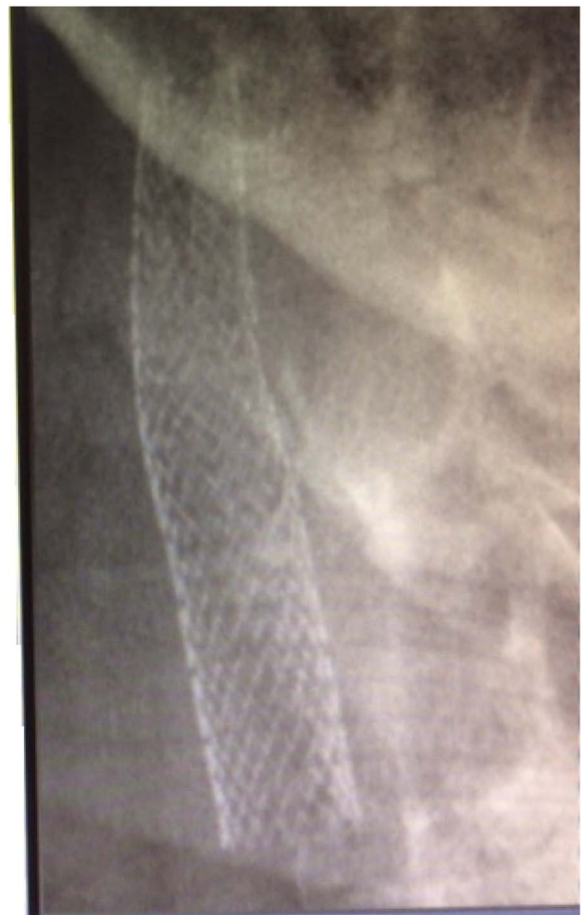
AP neck X-ray 6 weeks post-stenting.
